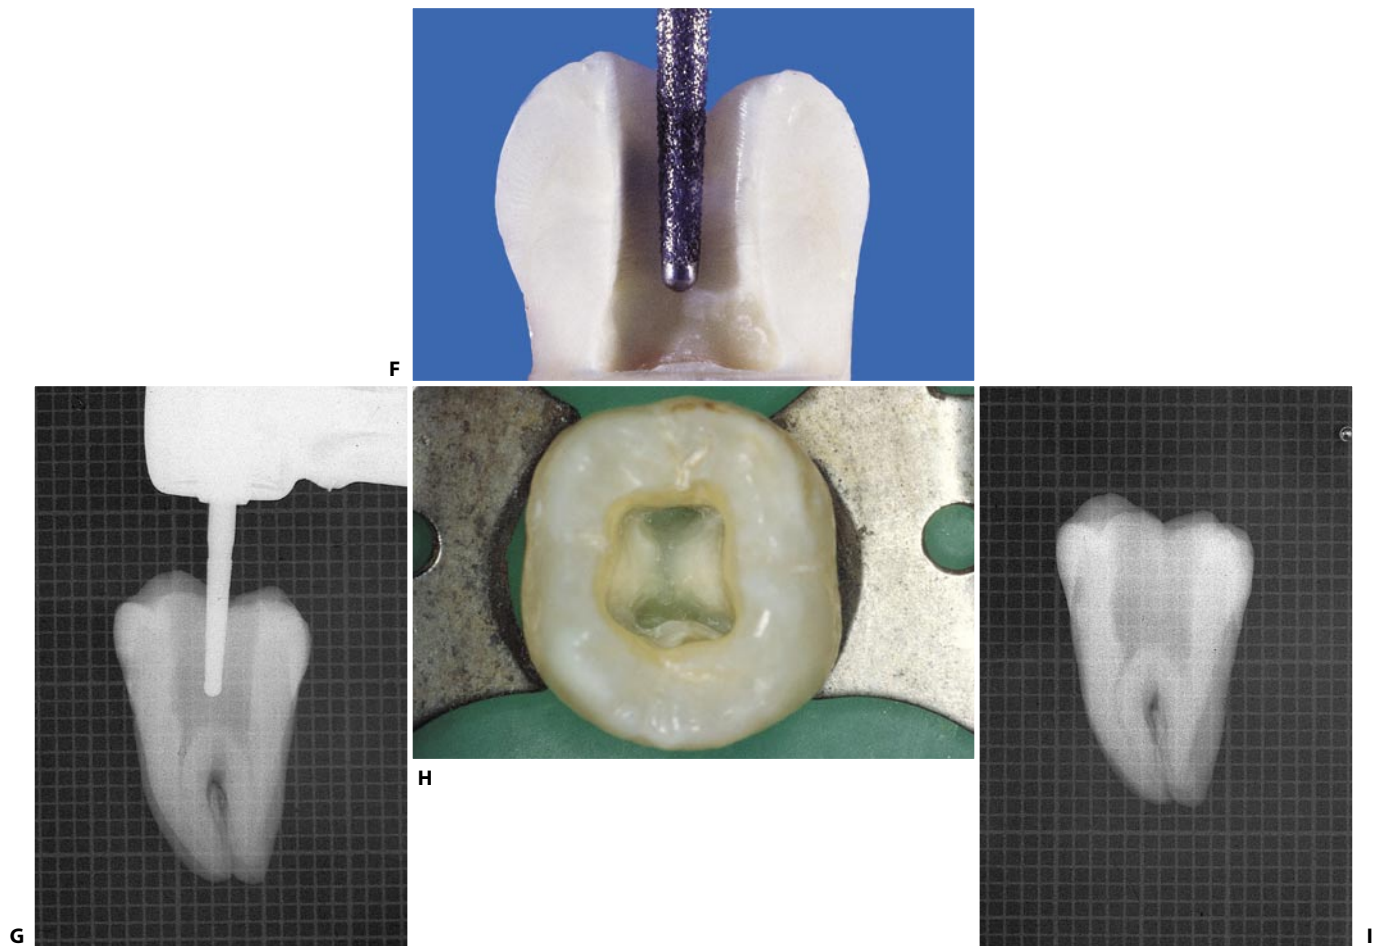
(continued) F. The non-cutting diamond bur performs the finishing and flaring phase. G. Radiographic appearance of this phase. H. Completed access cavity. I. Radiographic appearance of the access cavity.
